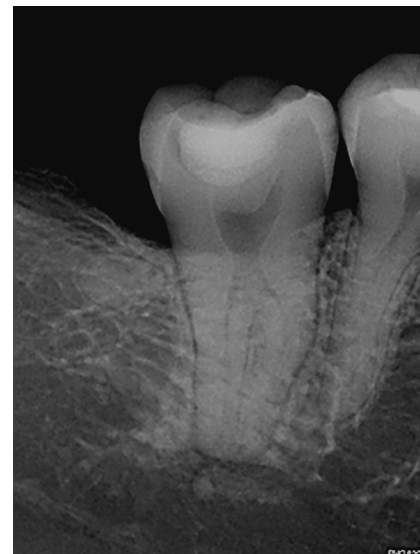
(Periapical radiograph of mandibular second molar.
